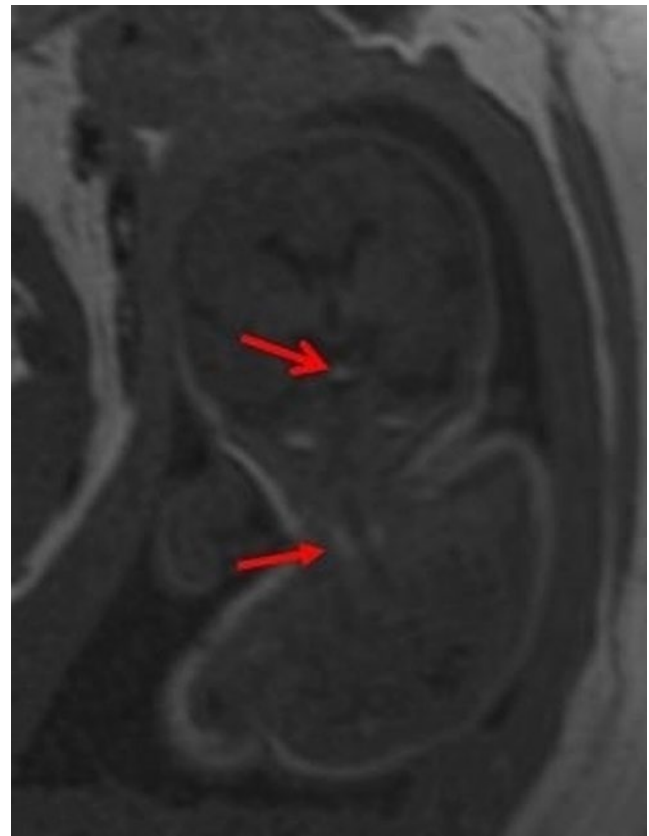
Coronal T1-weighted image of a fetus at 35+3 GW. The hypophysis (*open arrow*) can be clearly discerned as a hyperintense focus. In addition to that, the lobes of the thyroid gland (*closed arrow*) can be seen as hyperintense foci
